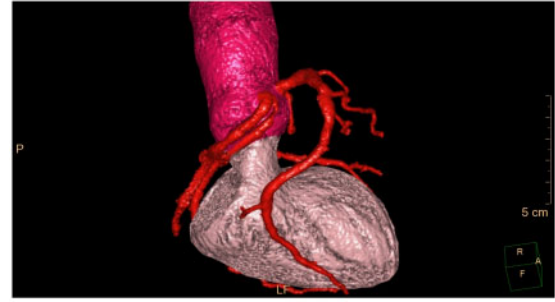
Three-dimensional reconstruction computed tomography coronary angiography reconstruction showing separate origins of all three coronary arteries from the right coronary sinus, with the left anterior descending and left circumflex arteries having retroaortic, non-malignant courses.
